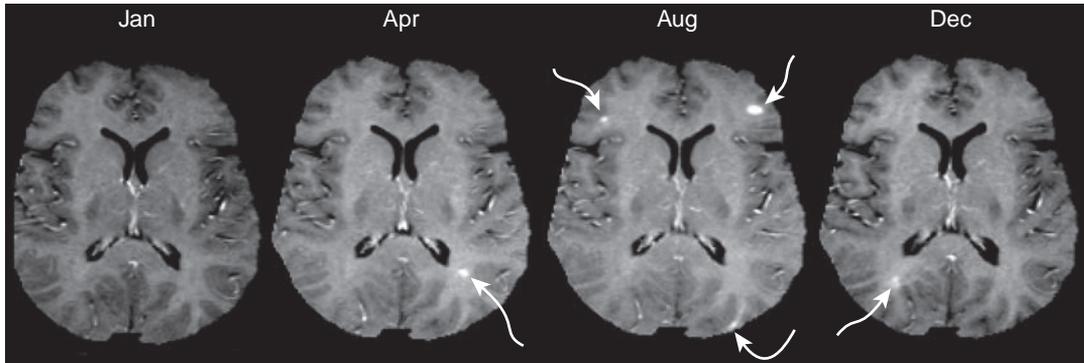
• Serial MRI scans at the same level for the same patient with multiple sclerosis show how lesions appear and recede over the course of 1 year.
